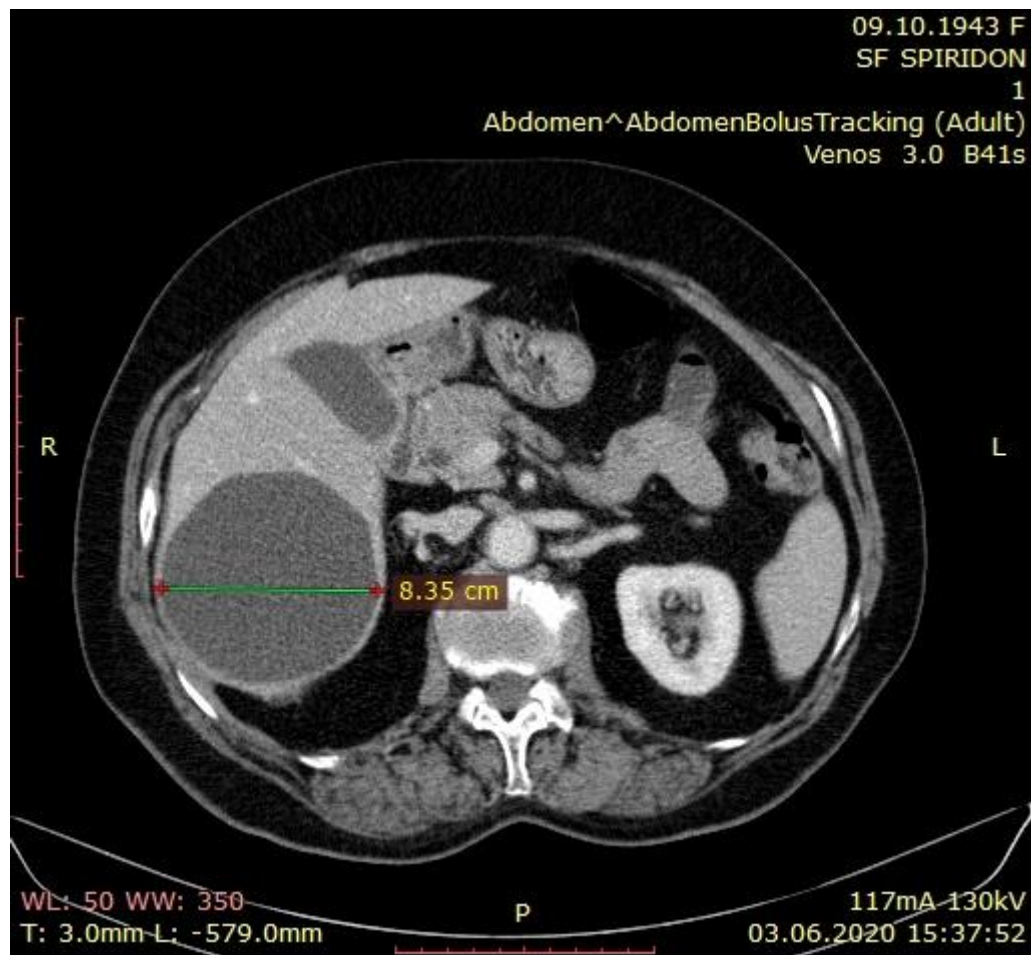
CT- cystic formation hepatic segments VI-VII-VIII
